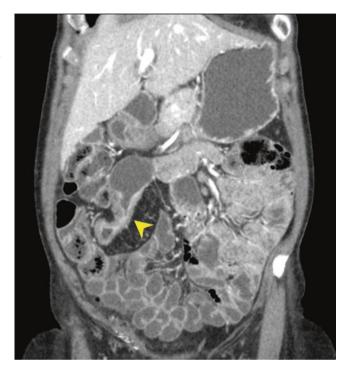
CT enterography coronal images demonstrating an ileal stricture with pre-stenotic dilation in a patient with Crohn's disease
